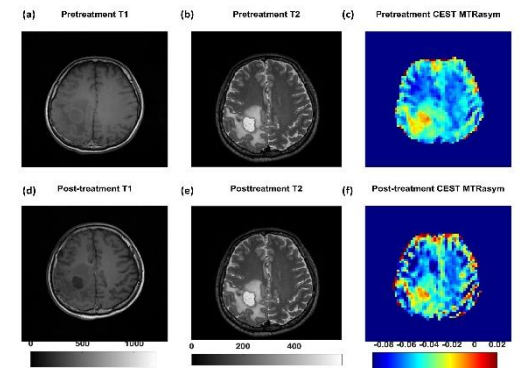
Representative brain MRI images from Patient 2. Pre- and post-treatment of (a,d) T₁-weighted imaging, (b,e) T₂-weighted imaging, and (c,f) CEST MTR_{asym} (3.5 ppm)
